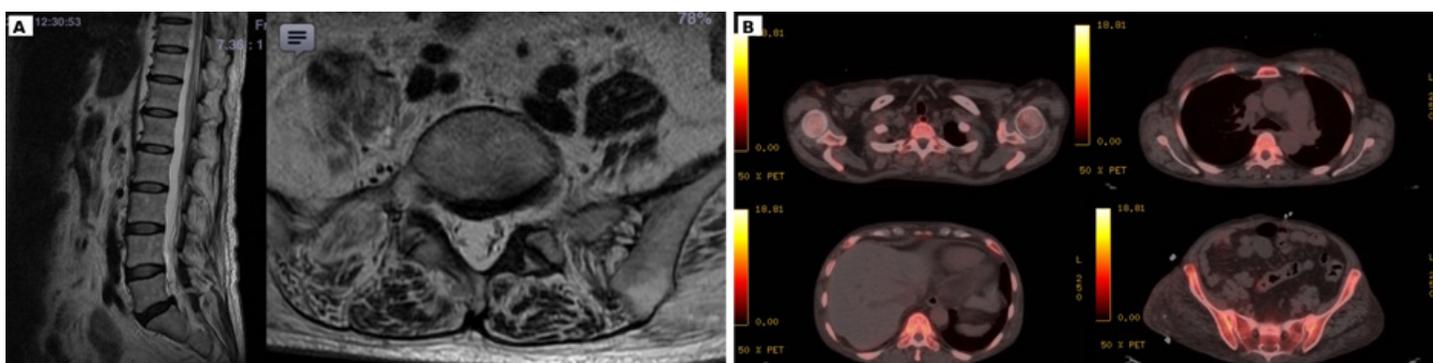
Systemic imaging used during the diagnostic work-up. (A) Lumbar spine MRI showing multilevel degenerative changes without compressive lesions; (B) whole-body PET/CT without focal hypermetabolic primary or osseous lesions, helping to exclude oncologic causes of a pathologic fracture.
